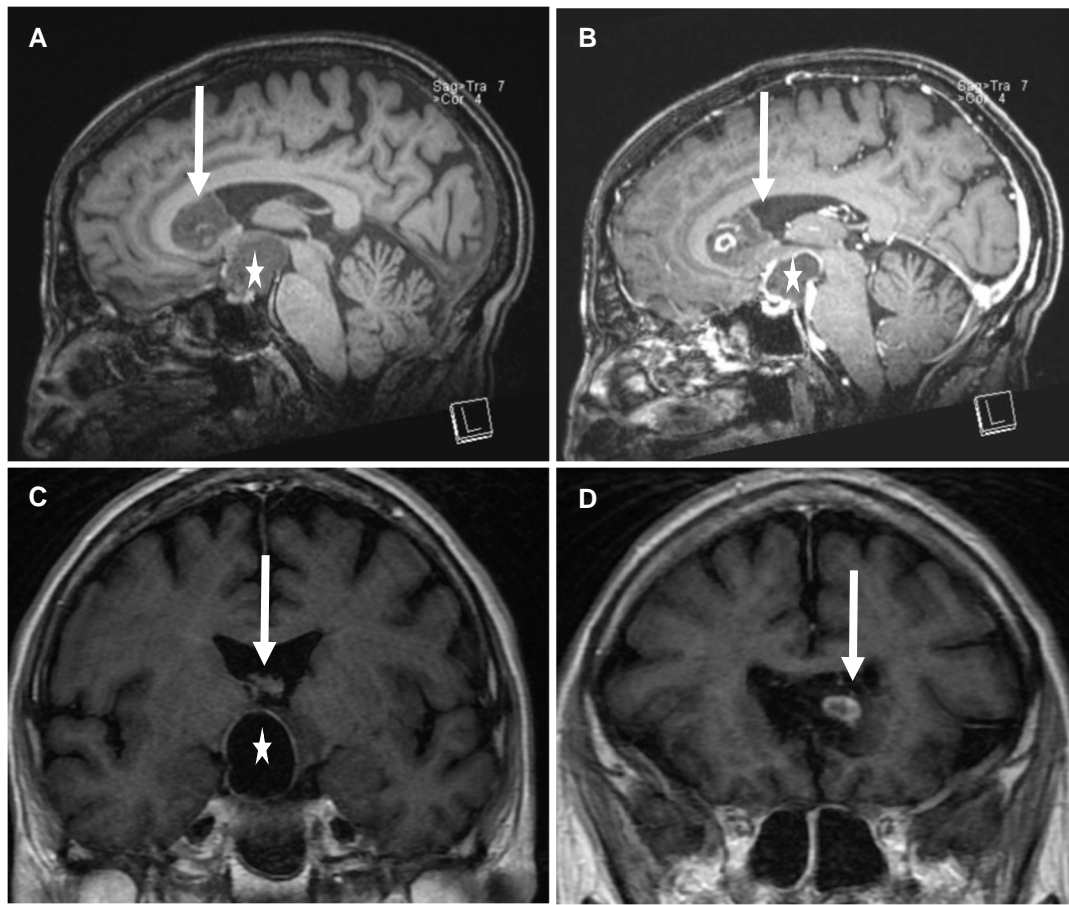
Pre-operative brain imaging demonstrating two synchronous brain tumors. (A) Pre-contrast brain MRI, sagittal view; (B) Post-contrast brain MRI, sagittal view; (C) Post-contrast brain MRI, coronal view. The arrows point to the third ventricle glioma and the stars indicate the craniopharyngioma. In both images, cortical brain atrophy is evident.
